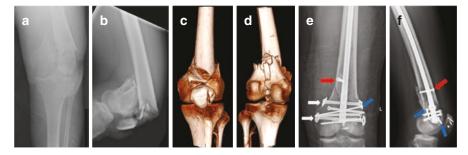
(a, b, c and d) Preoperative radiographs and 3D CT scan reconstructions demonstrating a comminuted, intra-articular distal femur fracture in a 32-year-old male involved in a high-speed motorcycle accident. The distal femur fracture was an open injury (Gustilo grade 3). (e and f) Postoperative radiographs demonstrating anatomic
